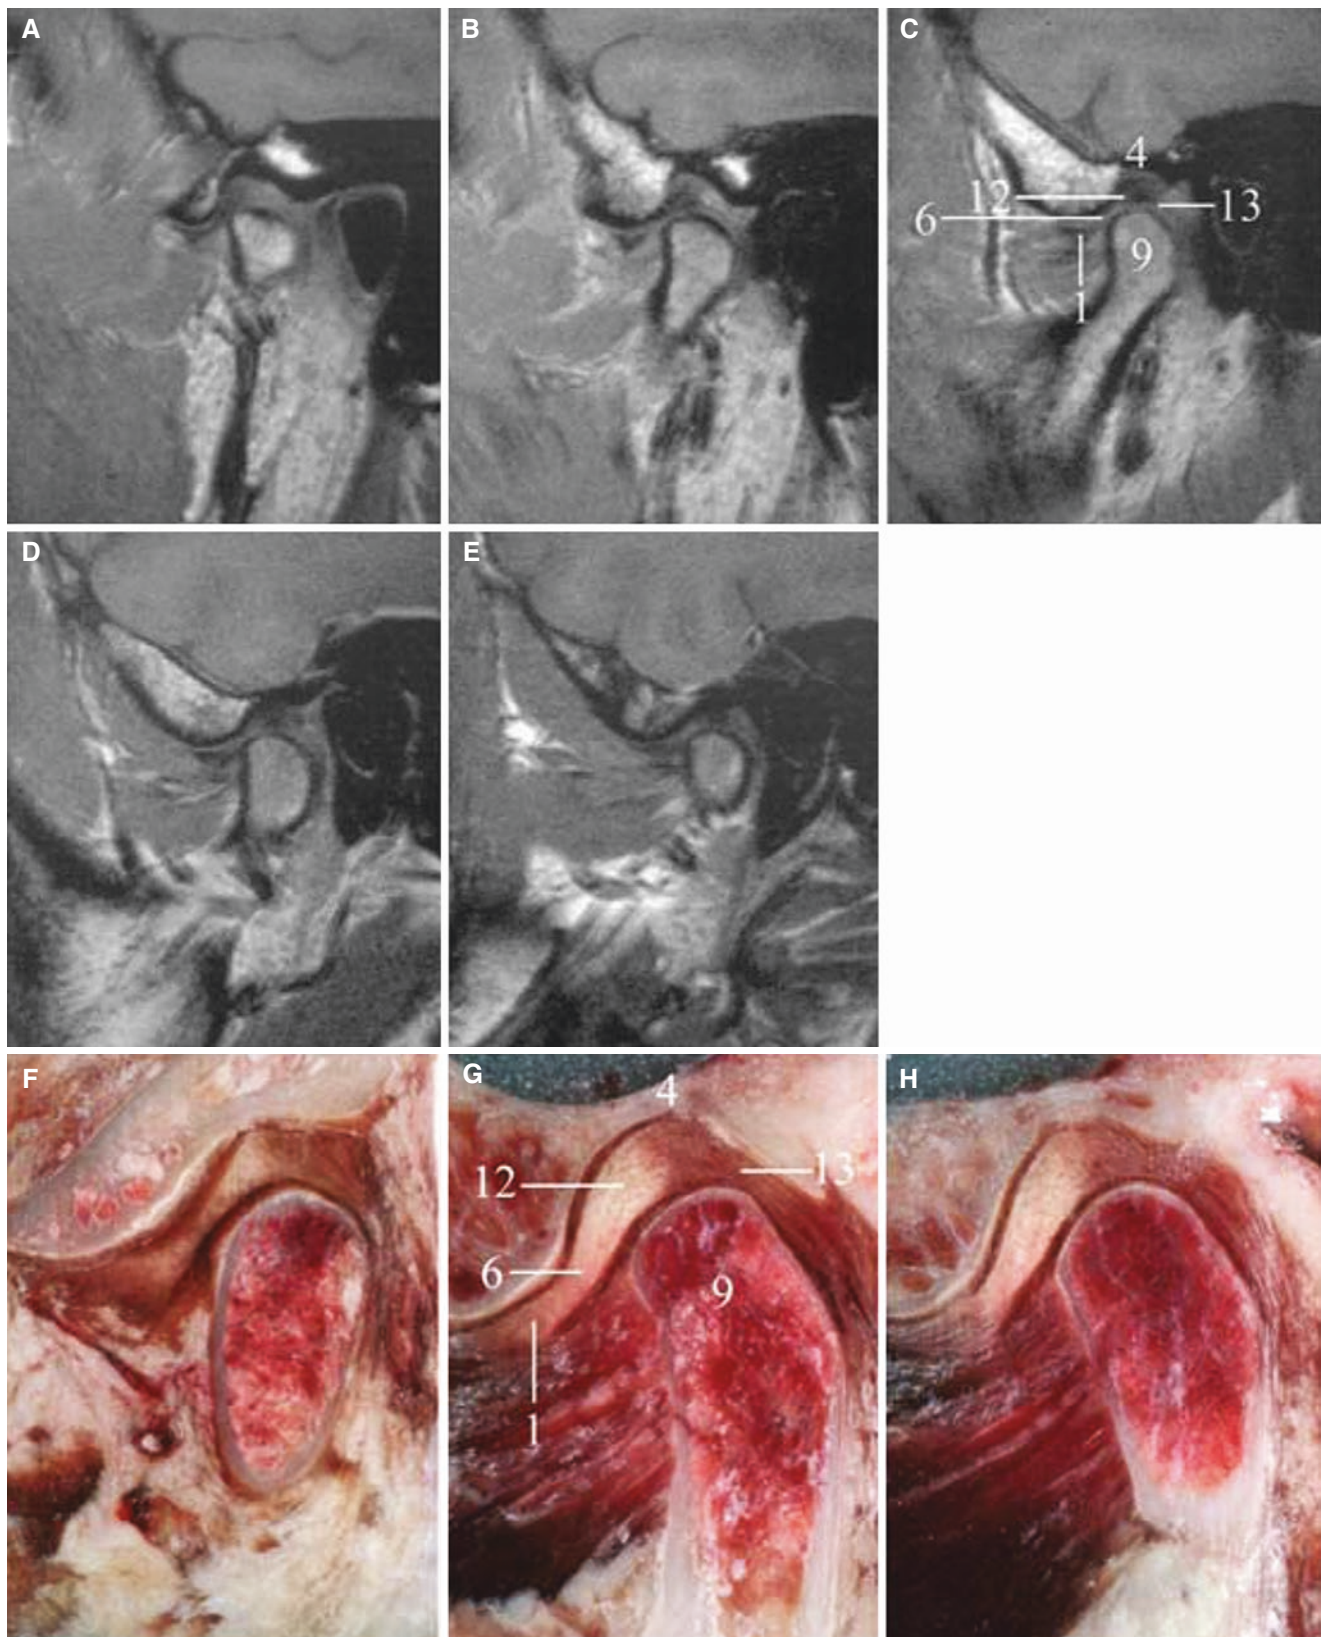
Normal bone and disc anatomy throughout joint, asymptomatic volunteer; oblique sagittal MRI from lateral (A) to medial (E). Oblique sagittal autopsy sections from lateral (F) to medial (H)
